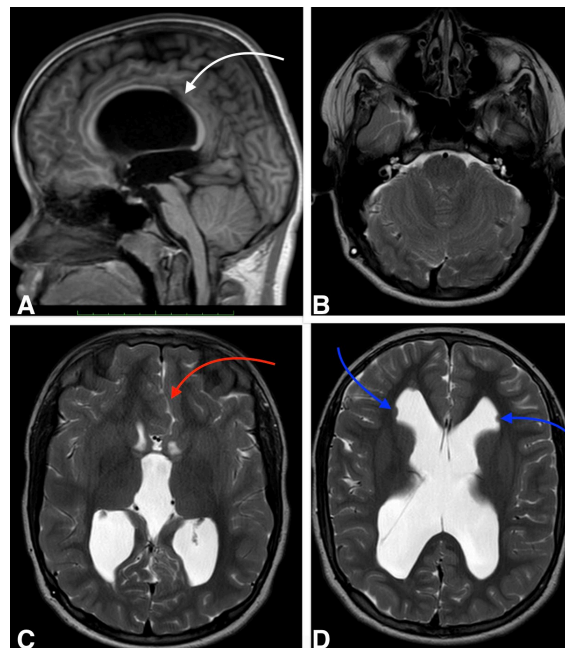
(A) Sagittal T1-weighted image showing posterior corpus callosum dysgenesis with absence of the posterior body (*white arrow*); (B) Axial T2-weighted image demonstrating dysplastic vermis and cerebellar hemispheres; (C) Axial T2-weighted image showing abnormal cortical organization with bilateral stenogyria and interdigitating cingulate gyri (*red arrow*); (D) Axial T2-weighted image demonstrating triventricular hydrocephalus, agenesis of the septum pellucidum and multiple periventricular nodular gray matter heterotopia along the frontal horns (*blue arrows*).
